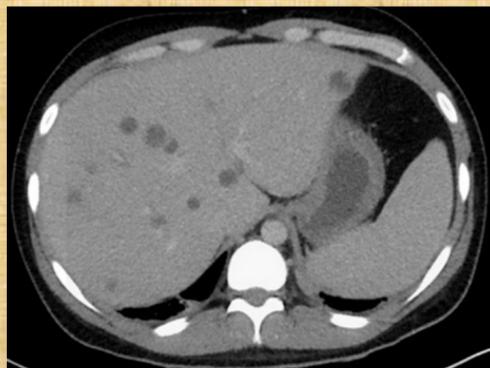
CT TAP showing liver and lung involvement
